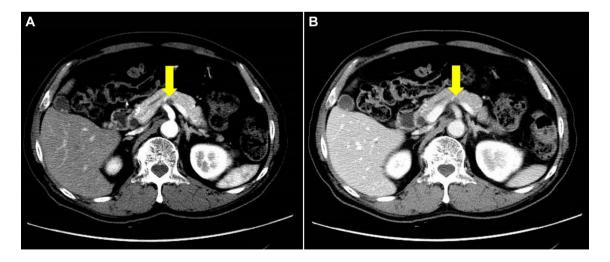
Abdominal contrast-enhanced computed tomography (CT) showed a 9-mm hypovascular tumor in the arterial phase (arrow, a) and the lesion was slightly enhanced in the portal phase (arrow, b)
